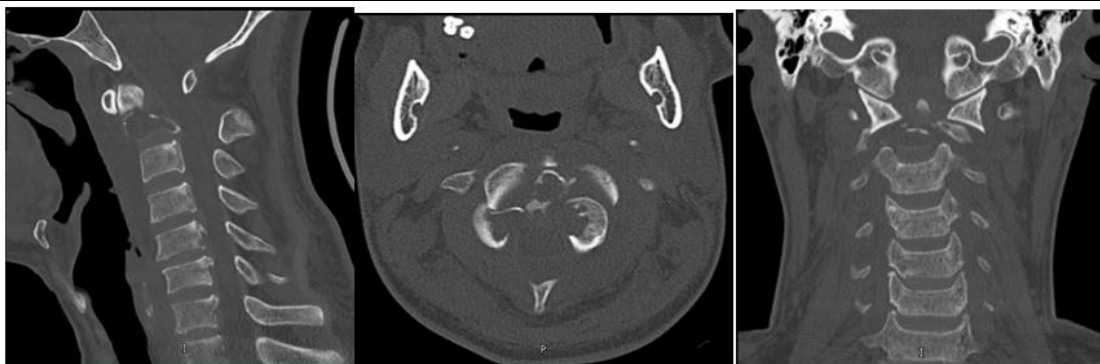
Brain and cervical spine CT scan conducted in the emergency department obviously showing destruction of the C2 vertebrae.
